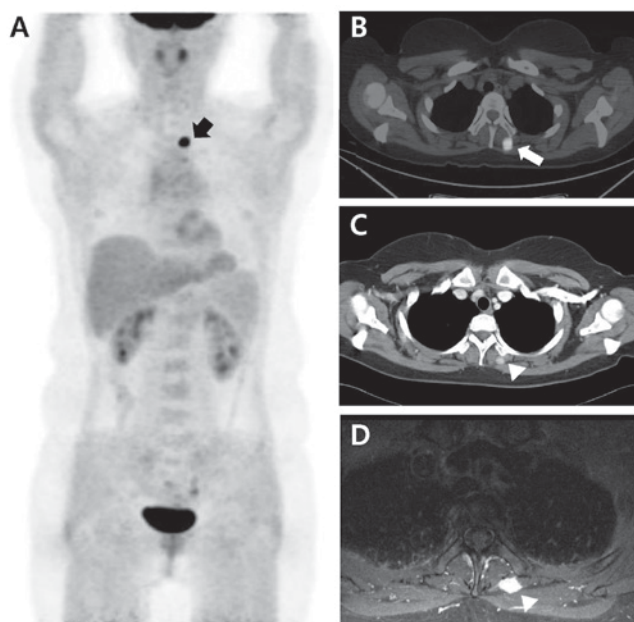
Fluorodeoxyglucose PET/CT shows a focal hypermetabolic lesion in the left paraspinal muscle at the level of T3 on (A) maximum intensity (black arrow) and (B) axial fused PET/CT images (white arrow). (C) Enhanced CT and (D) magnetic resonance imaging show a well-demarcated nodule with enhancement (white arrowhead). PET, positron emission tomography; CT, computed tomography.
